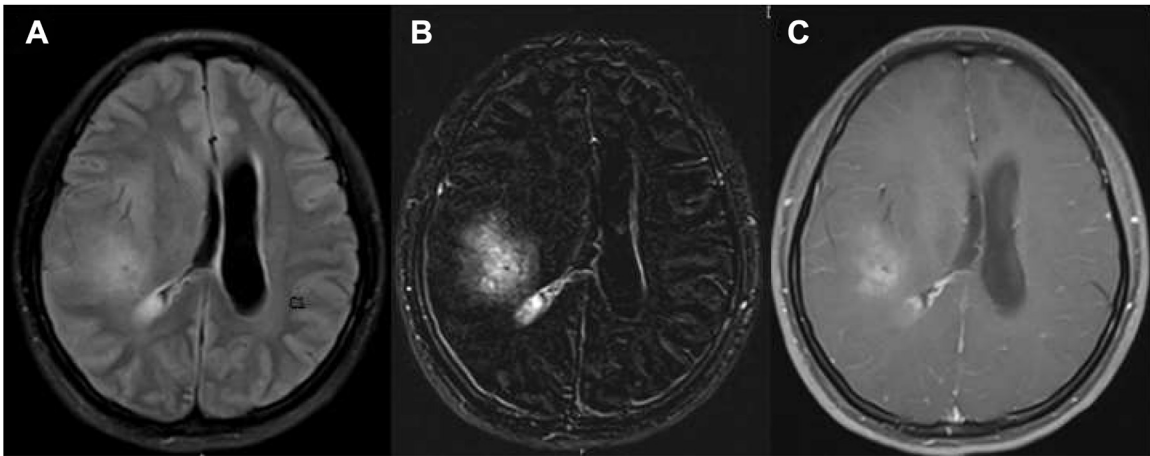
(A-C) shows that the MRI T2 -flair sequence, enhanced scanning silhouette, and enhancement maps show a patchy and markedly enhanced focus in the posterior horn of the right ventricle, suggesting that the lesion involves the right lateral ventricle.
